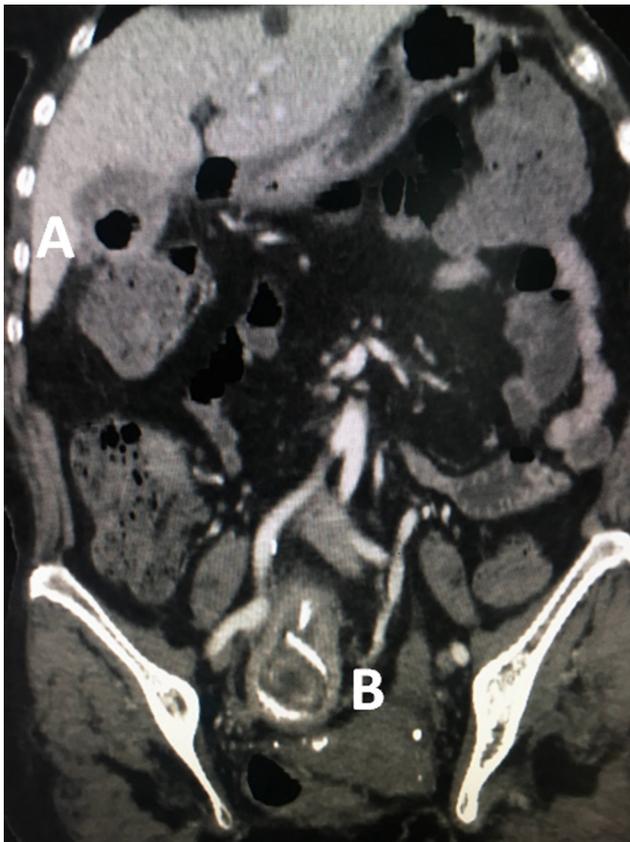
Computed tomography of the abdomen and pelvis with contrast injection (portal time). Frontal slice through (A) the cholecysto-colonic fistula; and (B) the intra-sigmoidal stone.
